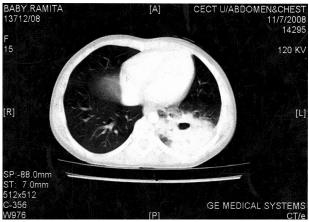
Contrast enhanced computed tomographic image of the chest showing consolidation in the left lowere lobe with a central area of cavitation showing an air pocket with septations.
